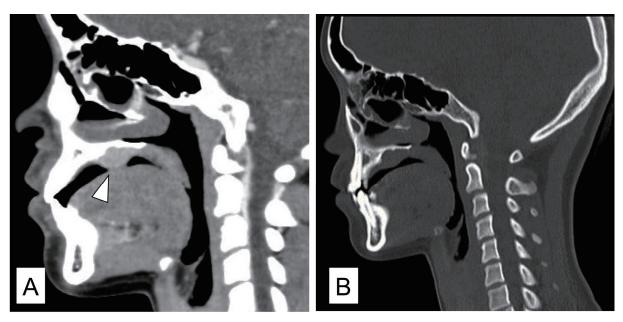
A. Contrast-enhanced CT, sagittal view. A well-defined mass with heterogeneous weak enhancement in the left side of the hard palate (Arrow).
